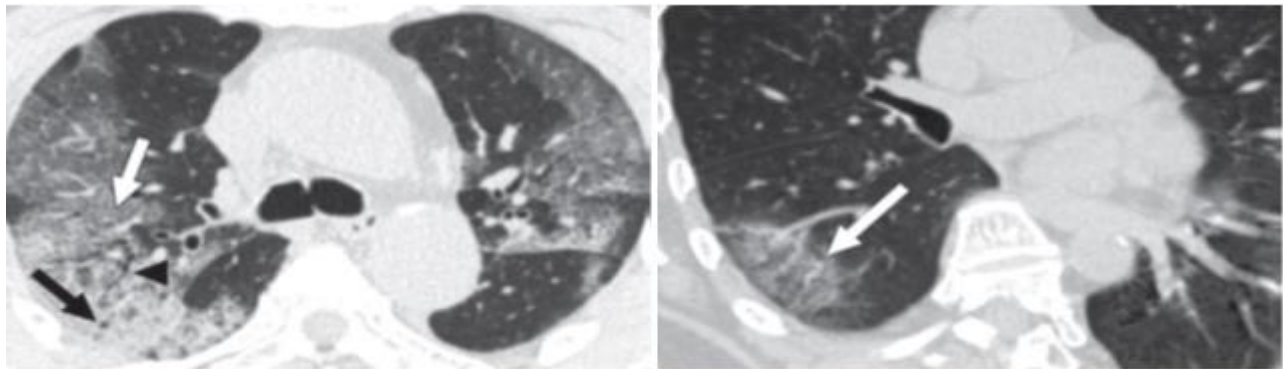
A 77-year-old woman with COVID-19. Transverse CT scan shows multiple GGO and consolidation with thickened intralobular and interlobular septum (white arrow). Air bronchogram sign (arrowhead) and air trapping (black arrow) are present (Lomoro et al., 2020).
